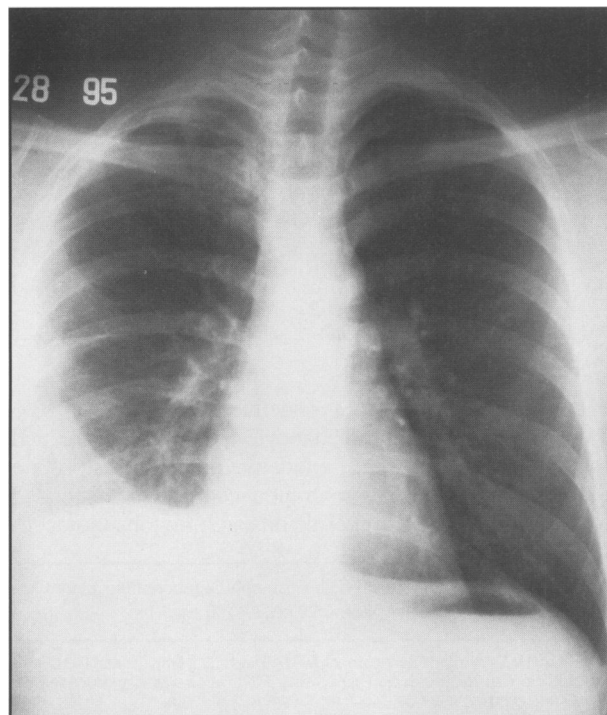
The chest roentgenogram at presentation reveals a moderate-sized right pleural effusion.
